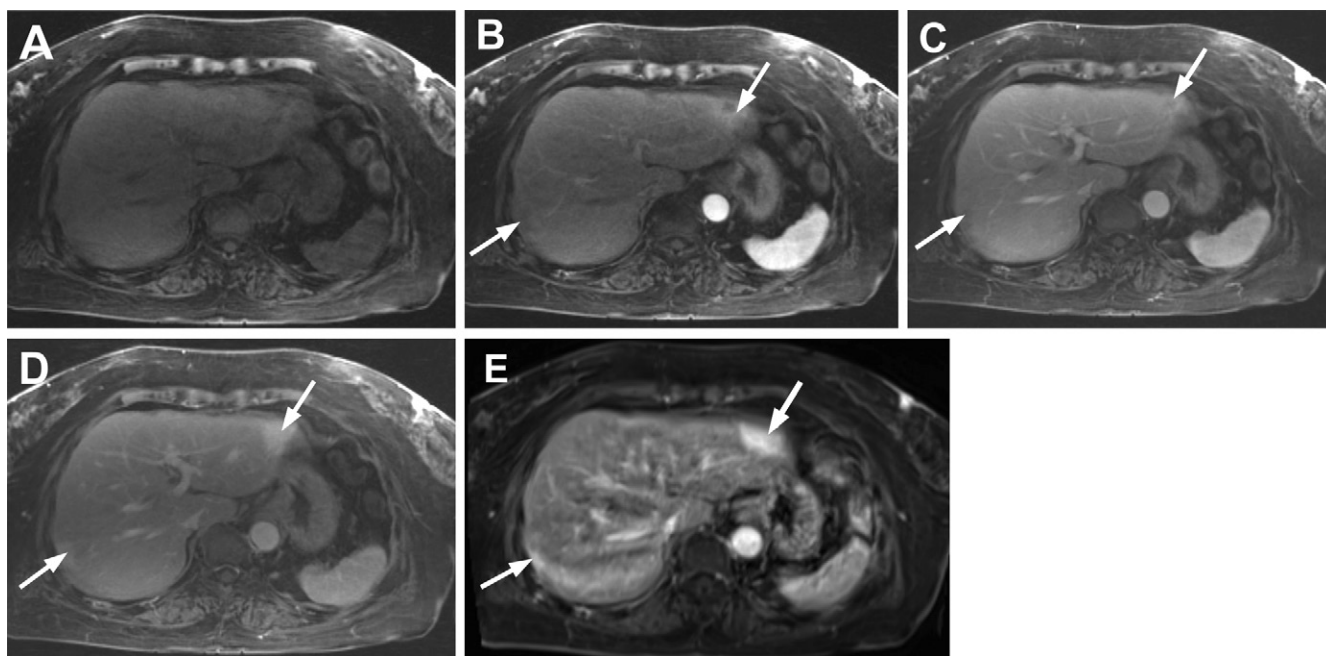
Axial free-breathing dynamic postcontrast images (golden-angle radial sparse parallel [GRASP]) in the same patient as in Figure 1, devoid of motion artifacts. Images obtained (A) before contrast material administration and (B) 30 seconds, (C) 60 seconds, and (D) 190 seconds after gadolinium-based contrast material administration. Contrast-enhanced images demonstrate peripheral complete rim of heterogeneous late arterial phase enhancement (B), thus excluding hemangioma, with progressive centripetal contrast material fill-in on the portal venous (C) and delayed phase images (D). (E) Conventional breath-hold contrast-enhanced axial T1-weighted MRI scan in delayed phase was also acquired after GRASP (the patient was injected only once with 6.1-mL dose of intravenous gadobutrol). Image shows avidly enhancing lesions in both lobes of liver. When compared to GRASP images, this breath-hold image shows significant motion artifacts limiting accurate lesion characterization. Arrows in B–E indicate lesions.
